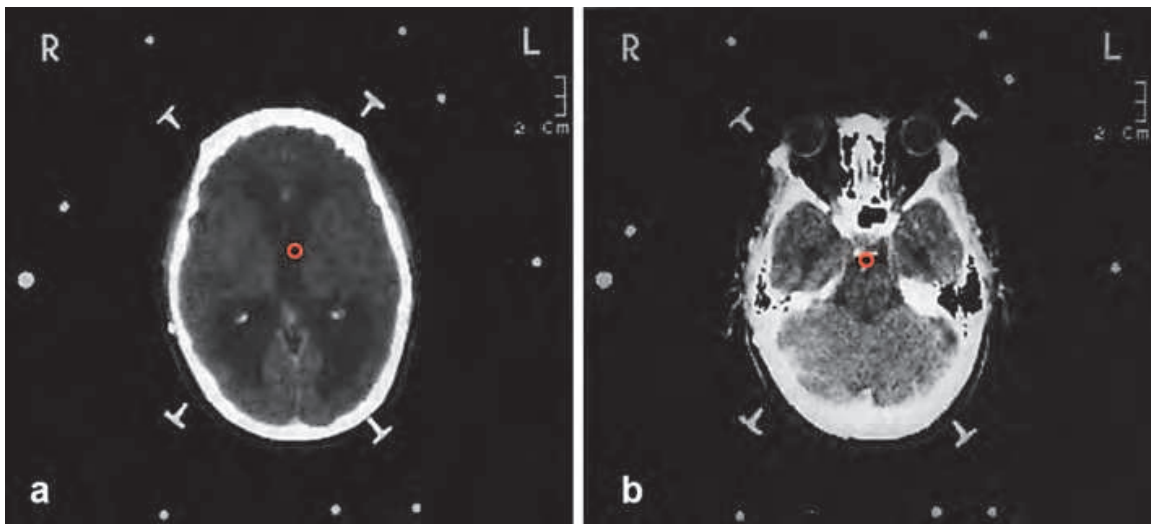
CT-based stereotactic calculation of two target points for the ventriculostomy. Calculation of the foramen of Monro visualized by a circle (a) and the target at the floor of the third ventricle between the dorsum sellae and the basilar artery in the midline (b).
